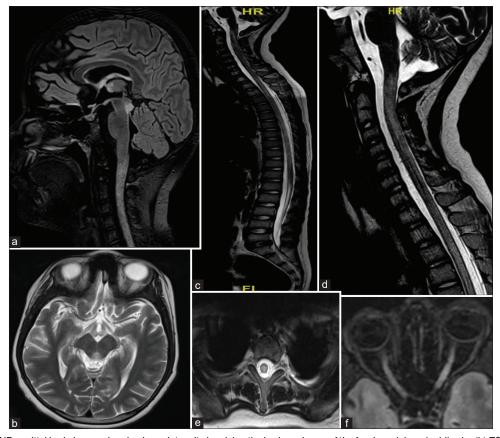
(a) T2 FLAIR sagittal brain image showing hyperintensity involving the body and crus of the fornix and dorsal midbrain. (b) T2 axial brain showing signal changes in the periaqueductal grey matter, mammillary bodies. (c, d) T2 spine sagittal image showing diffuse long segmental hyperintensity in the spinal cord extending from cervico-medullay junction to conus level involving dorsal and lateral columns. (e) T2 axial image showing hyperintensity in the spinal cord involving dorsal and lateral columns. (f) T2 FLAIR axial image of optic nerve cuts showing left optic nerve hyperintensity
